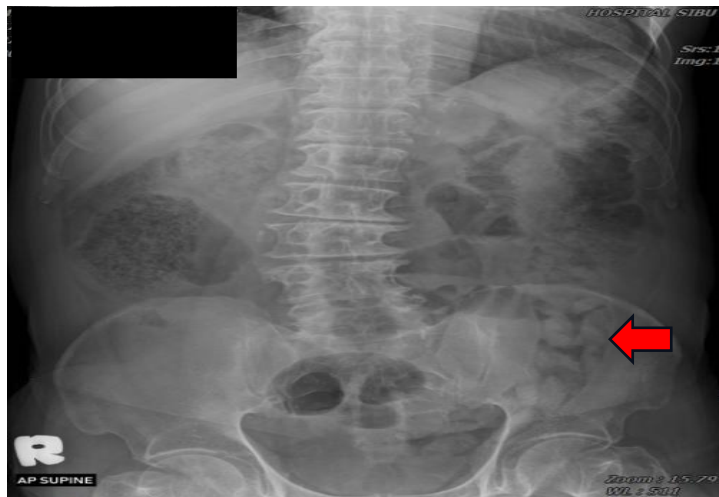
Abdominal X-ray showing multiple radio-opaque foreign bodies in the descending and sigmoid colon
